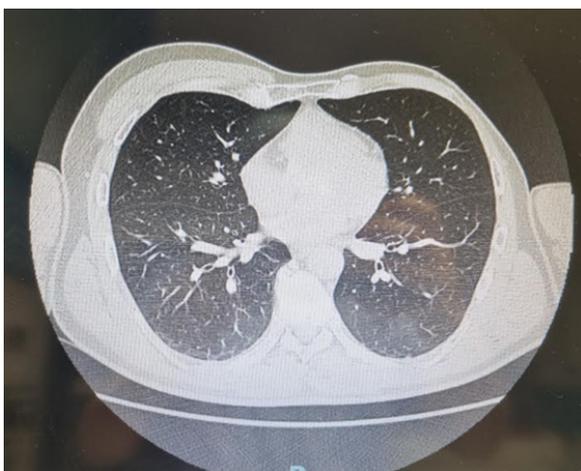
Axial computed tomographic images of the thorax showing: hypoplasia of the left pectoralis major muscle with absence of the heads with sternocostal insertion.
